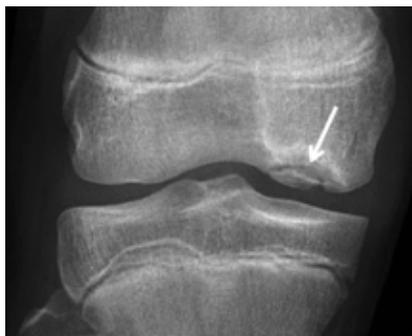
Radiographic (x-ray) view of an OCD lesion of the knee
